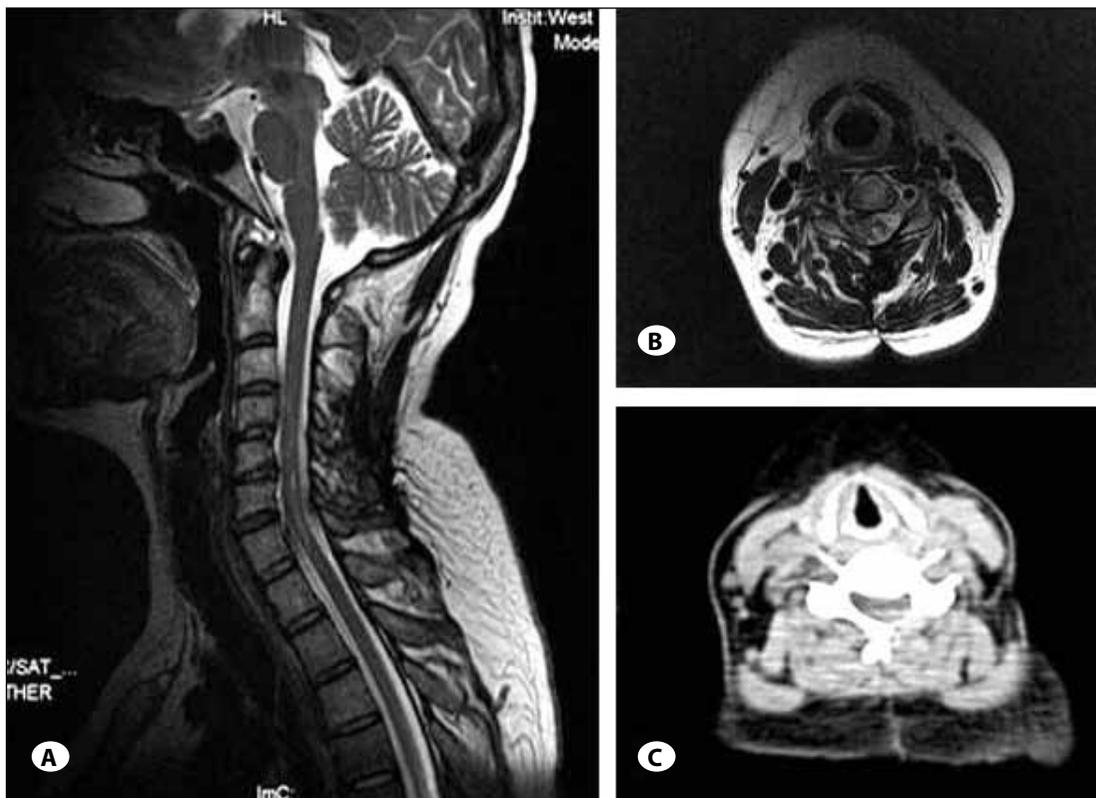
No bone destruction was found in the T2-weighted sagittal scan (A) and axial scan (B). Left hemilaminectomy was detected in the cervical CT scan (C).
